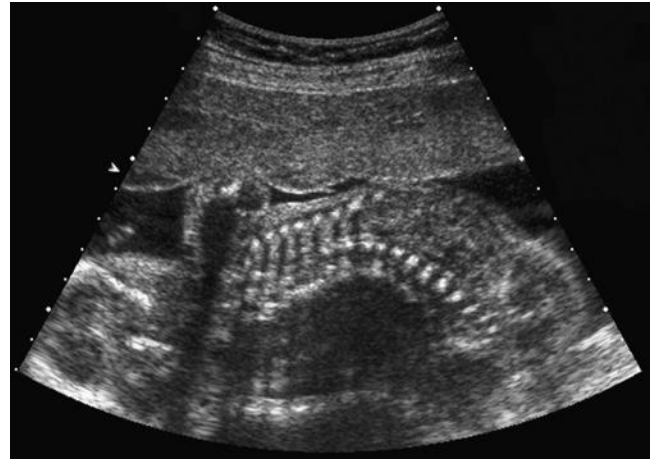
Coronal scan of the fetal spine by two-dimensional sonography showing scoliosis.
